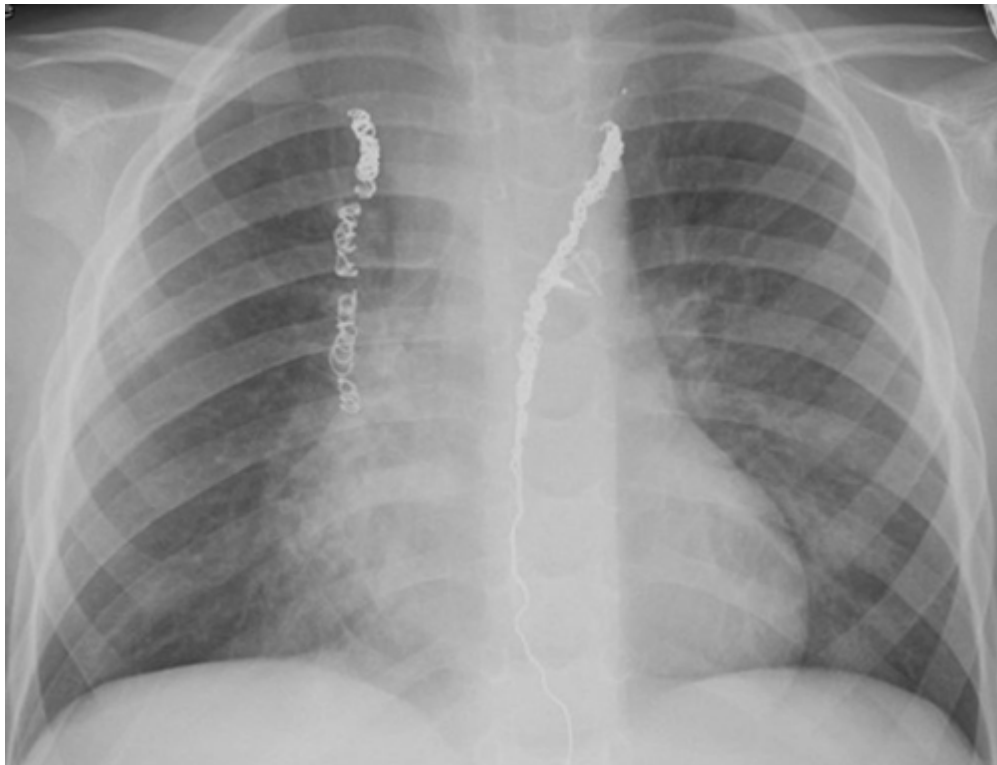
Chest radiograph with right middle lobe opacity. ↩
